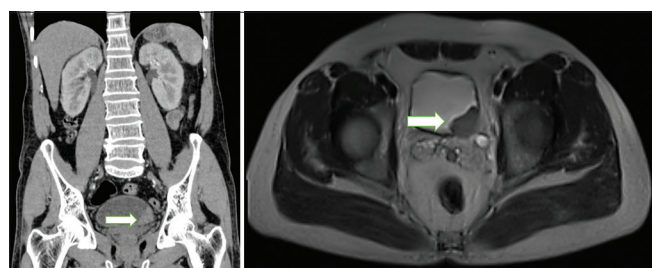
Coronal multiplanar reconstructions contrast-enhanced computed tomography image (left) shows vesical tumor in left posterolateral location (arrow) with similar findings on axial T2 weighted magnetic resonance image (right-arrow)
